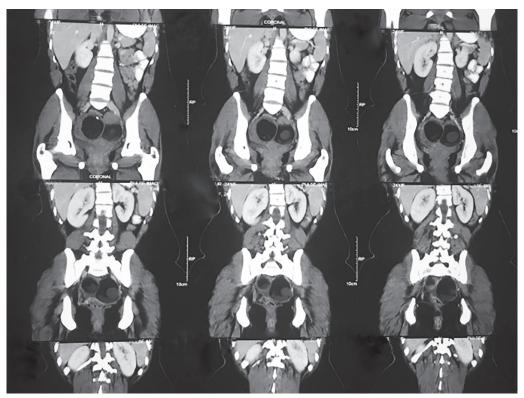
CT scan showing bilateral adnexal cysts with mixed echogenicity
